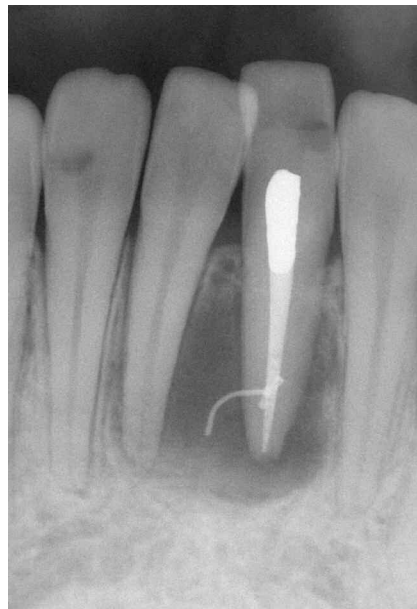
Endodontic post-operative radiograph.*
